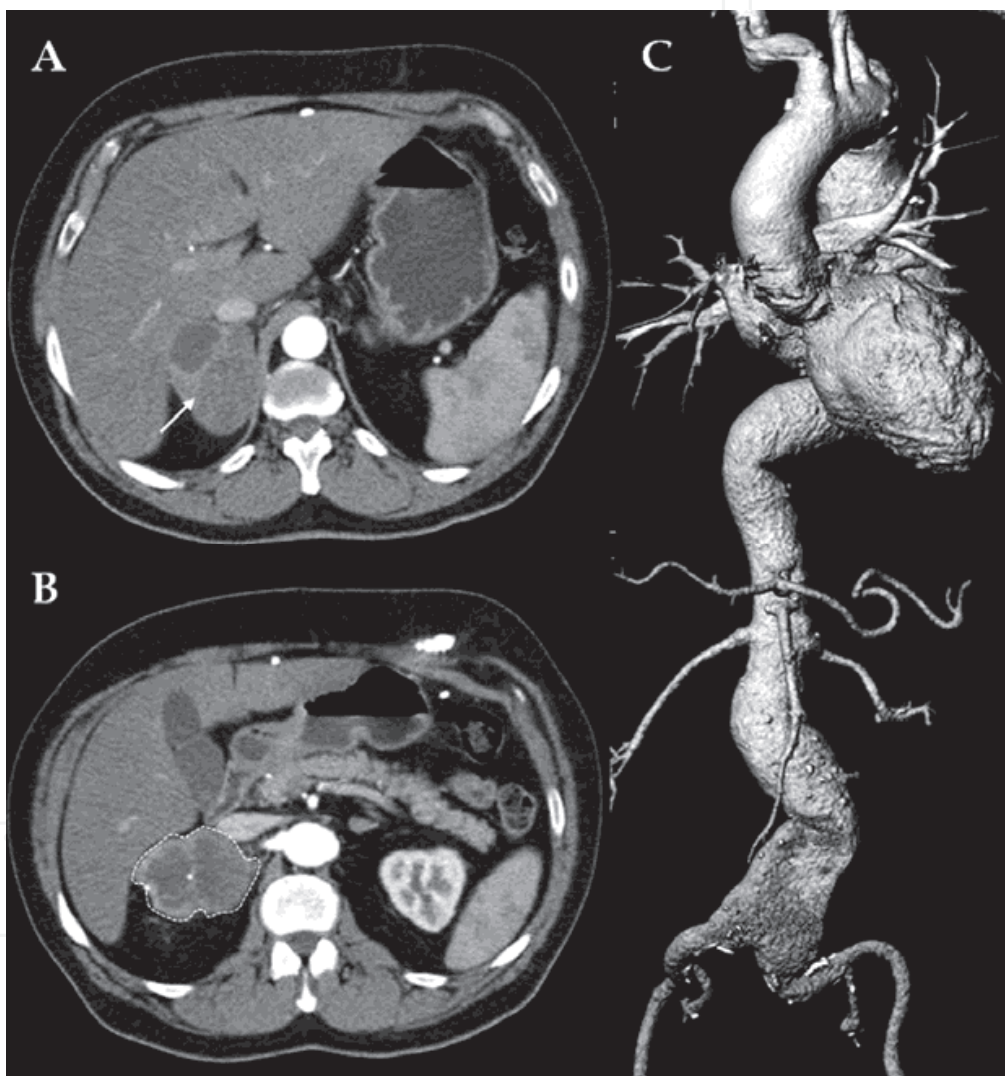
Preliminary CT-angiography showing the presence of a mass (A, *arrow*) protruding from the upper portion of the right kidney (B, *dotted line*) and a huge 6.5cm fusiform infrarenal AAA (C)
